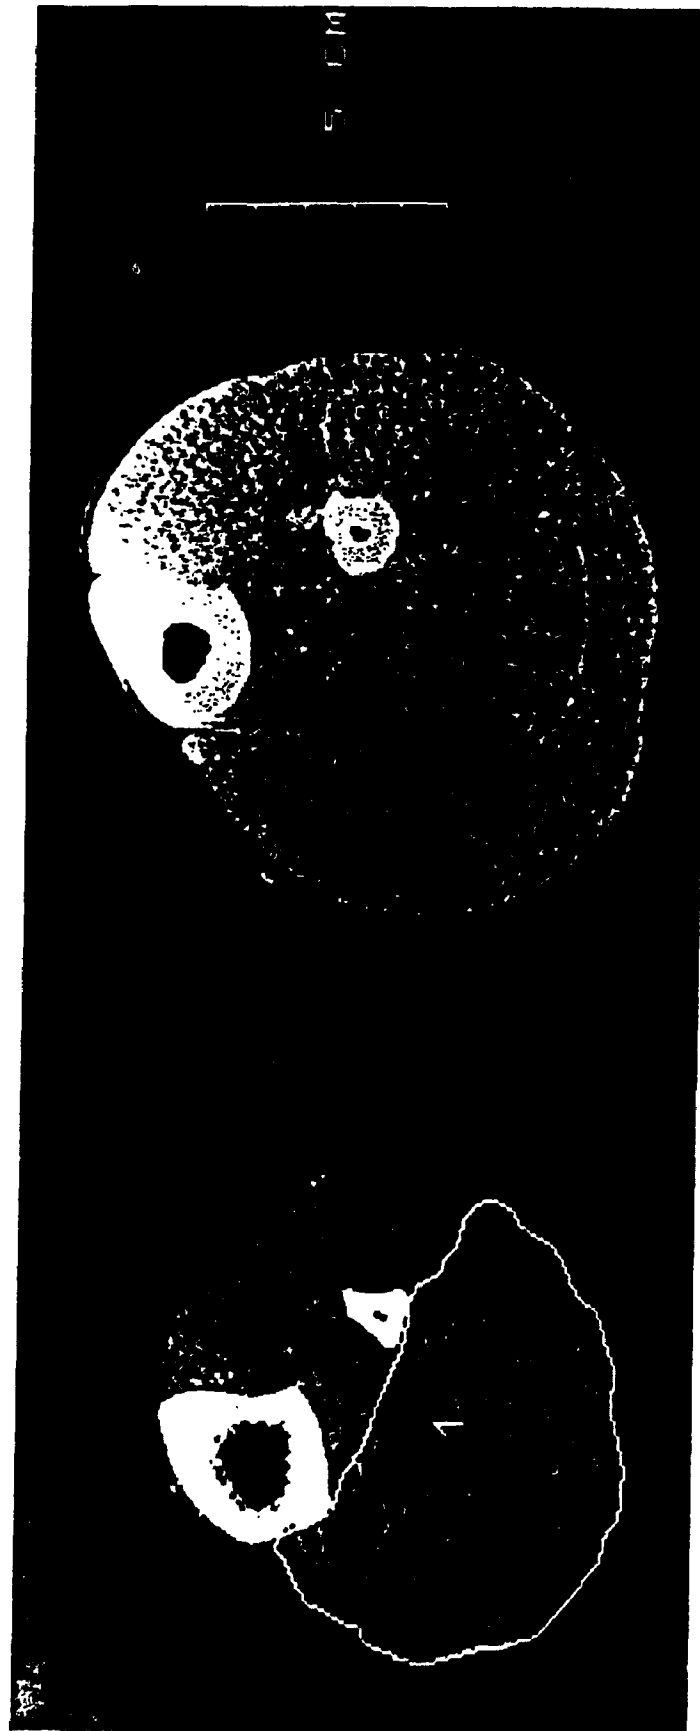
Computed tomography cross-section of left legs at the level of maximum girth from an 83y old (left) and a 27y old (right). The region outlined in the old leg (left) is the plantar flexor compartment. Less dense areas, not highlighted but appearing as black regions, correspond to non-muscle tissue within the outlined region.
